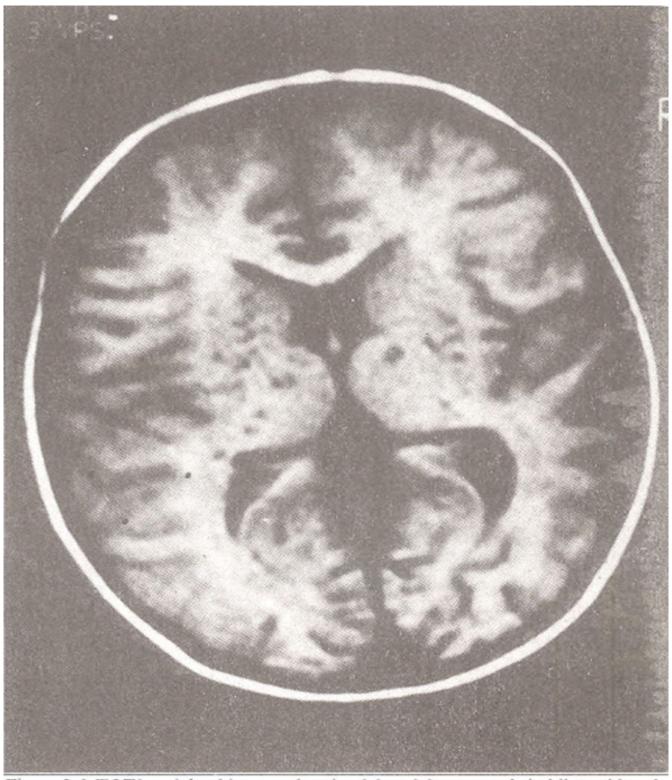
MRI T1 weighted images showing Moya Moya vessels in bilateral basal ganglia region.
